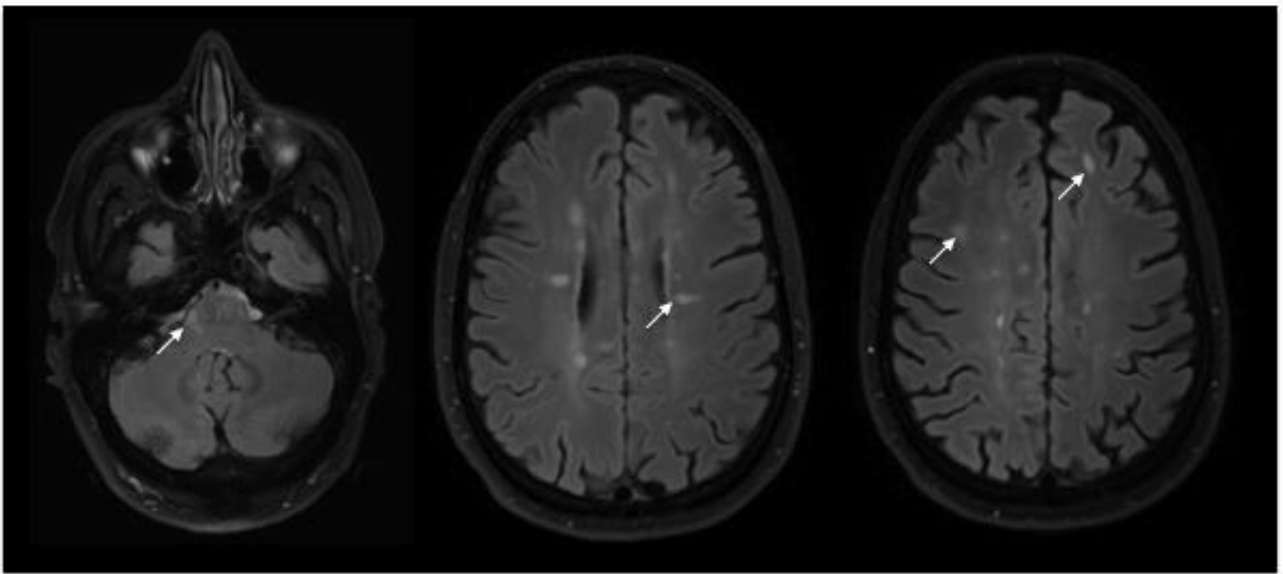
MS lesions visible as hyperintensities on FLAIR images. Left: Infratentorial lesion found in the pons (arrow). Middle: numerous periventricular lesions, some of which have classic ovoid shape (arrow). Right: subcortical lesions in frontal areas (arrows).
